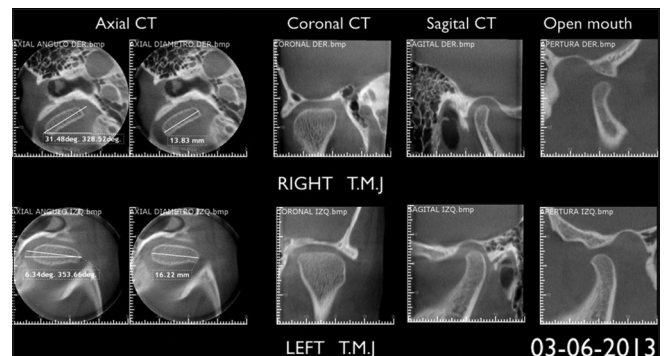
Pretreatment cone beam temporomandibular joints
